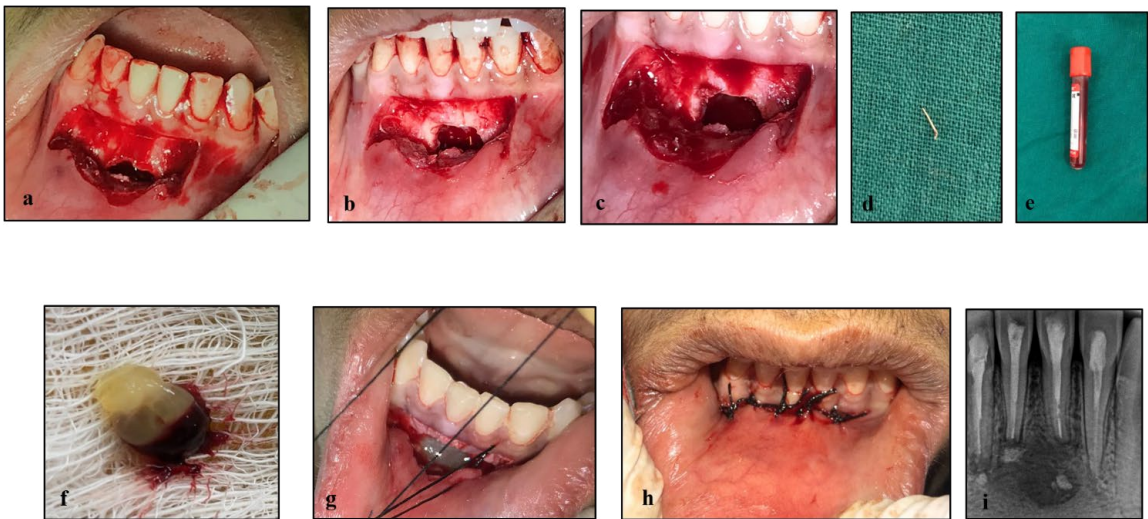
Intraoperative records, A: Flap reflection, B: Visualization of GP in periapical area, C: Debrided bony cavity, D: Retrieved GP, E: Blood Sample collection, F: PRF formation, G: P RF placed, H: Flap repositioning and suturing, I: Immediate post-operative IOPA
